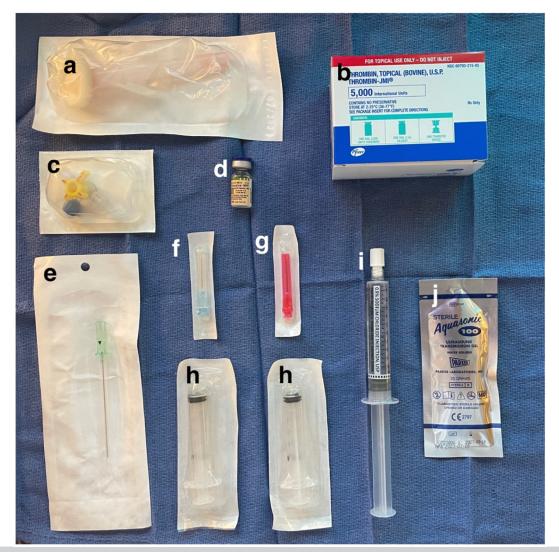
Supplies for thrombin injection. (A) Chlorhexidine skin prep. (B) Thrombin and diluent. (C) A three-way stopcock. (D) Lidocaine (1%). (E) AN 18G access needle. (F) A 25G infiltration needle. (G) Blunt-fill needle. (H) A 5-mL syringe. (I) Sterile saline flush. (J) Sterile ultrasound gel.
